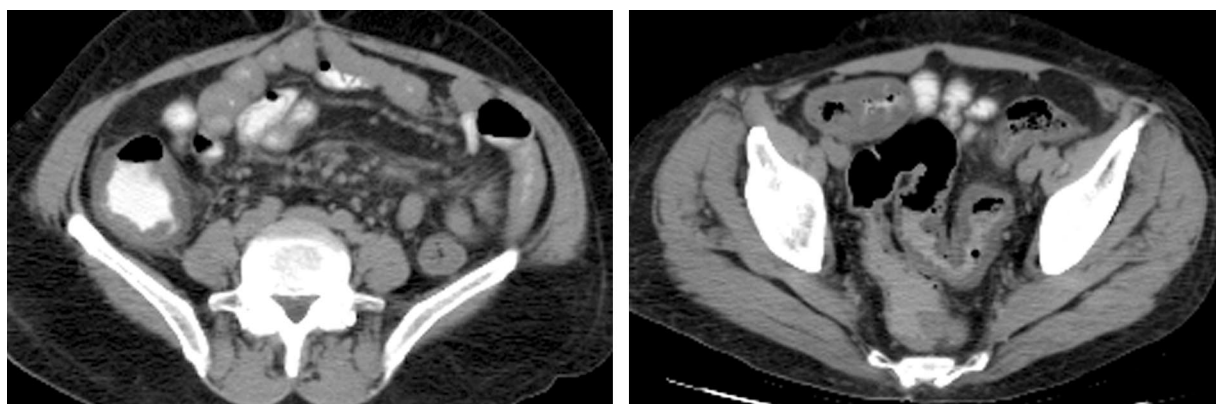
Pseudomembranous colitis following stem cell transplantation. CT scans show diffuse wall thickening and edema of adjacent fat in the cecum (a) and sigmoid colon (b).
